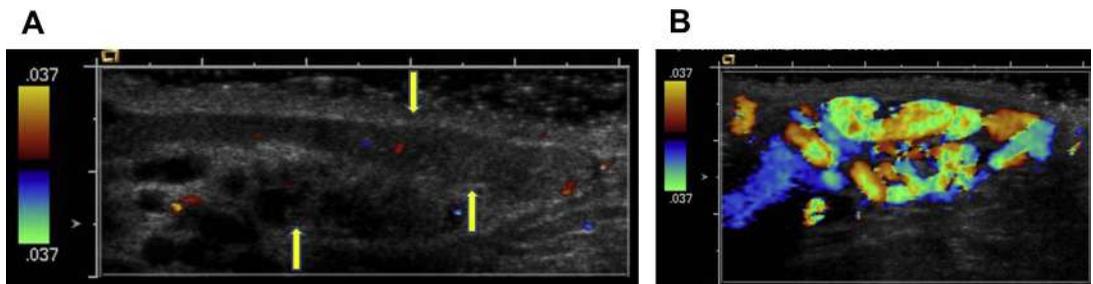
(A) Scrotal ultrasonography demonstrated dilated tortuous veins consistent with varicocele (arrows). (B) Doppler flow in patient with grade 3 varicocele.
